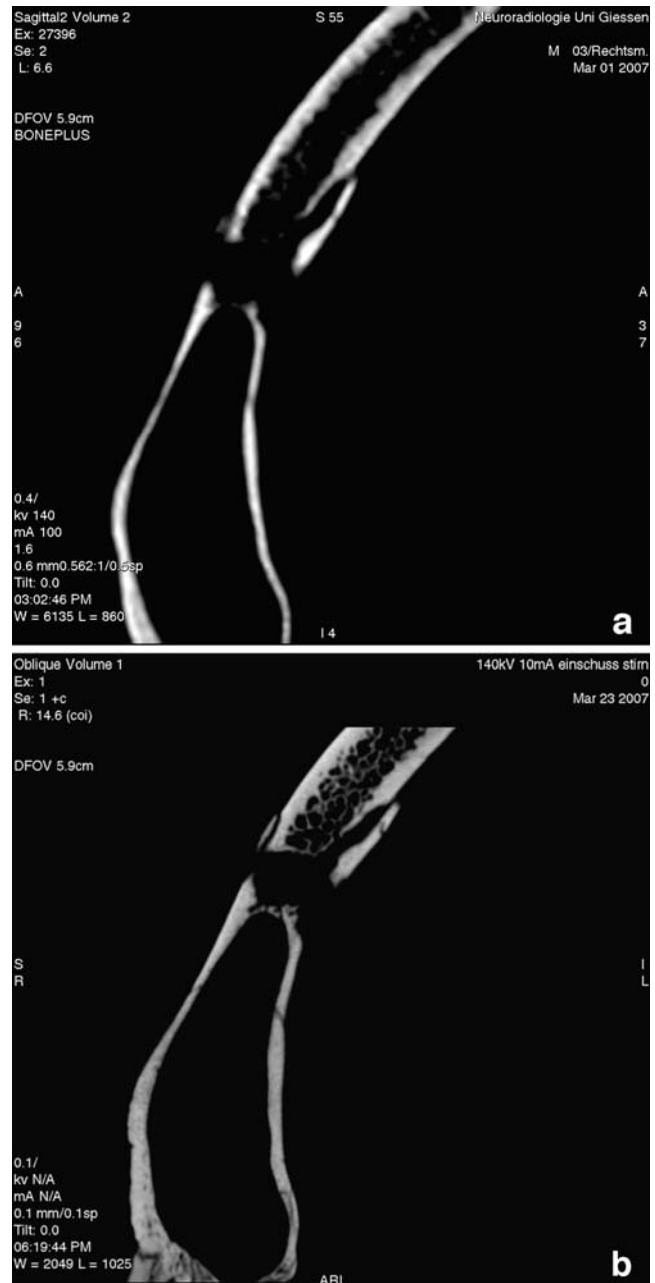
a, b Sagittal section plane image of the entrance defect in the forehead: a after MSCT and b after eLU-CT. The picture from the eLU-CT shows a greater wealth of detail
